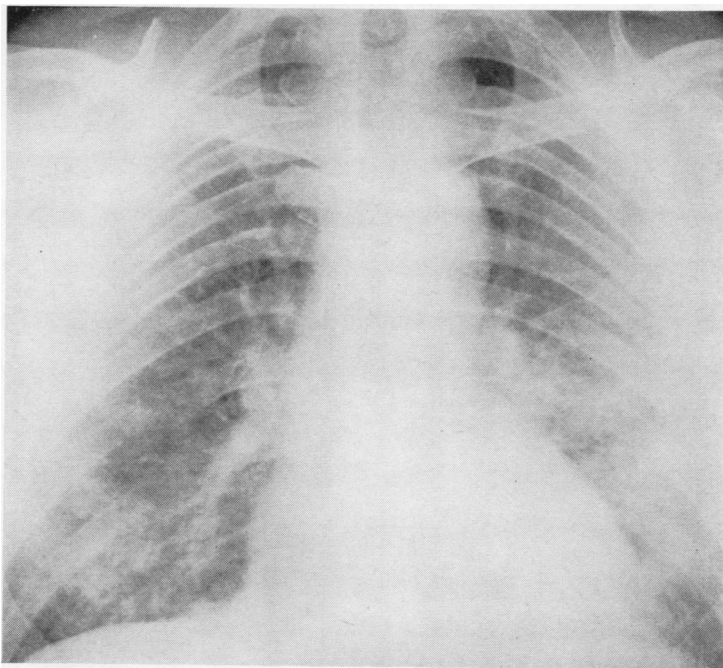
Case 1. Chest radiograph taken two weeks after the patient left work on a mushroom farm. Note soft confluent infiltration in the mid and lower zones of both lungs.*
